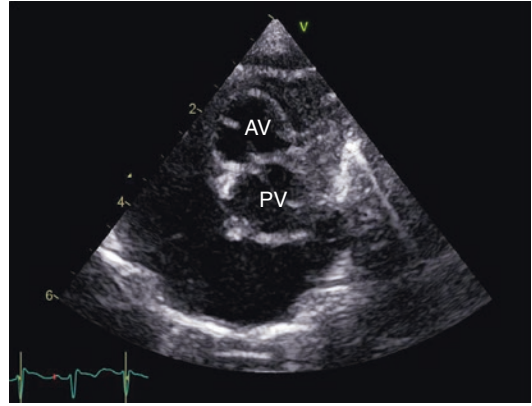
Parasternal short-axis echocardiography showing the aortic valve anterior and rightward from the pulmonary valve. AV aortic valve, PV pulmonary valve
